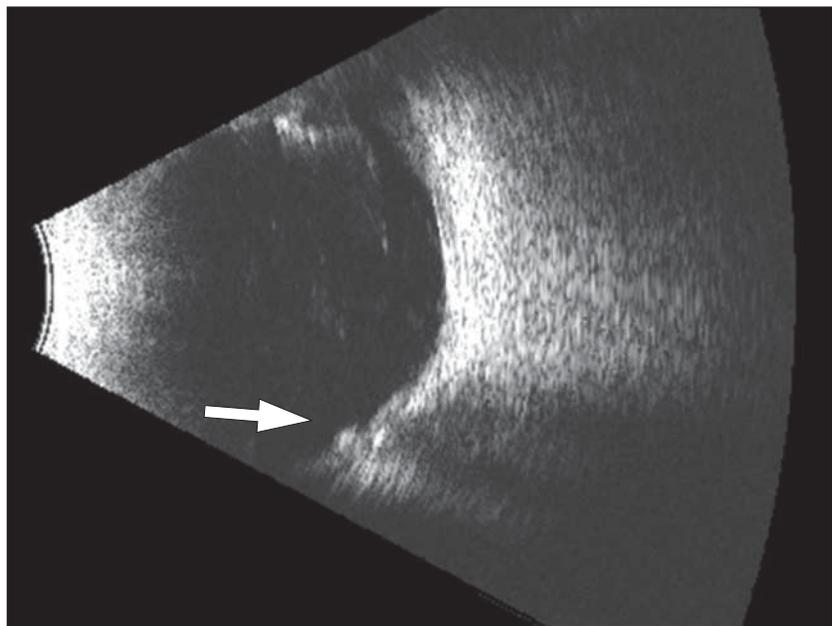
Ultrasonography of case 2 showing multiple vitreous opacities with an intraocular foreign body (arrow).
